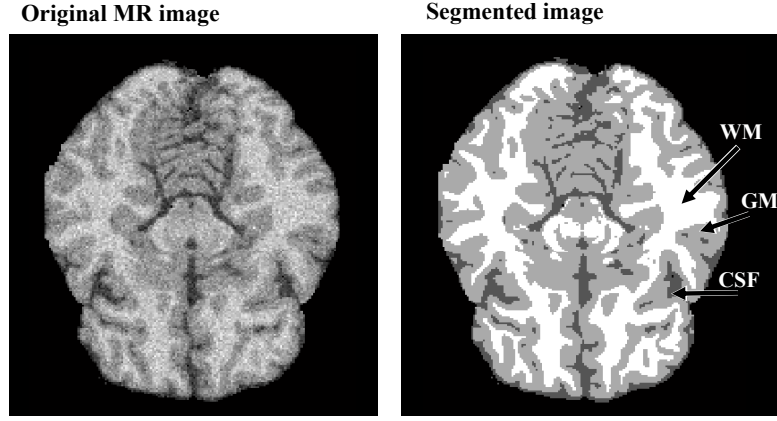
An example of the brain MRI segmentation with an original MR image (on the left) and segmented image with three labels: WM, GM and CSF (on the right).
